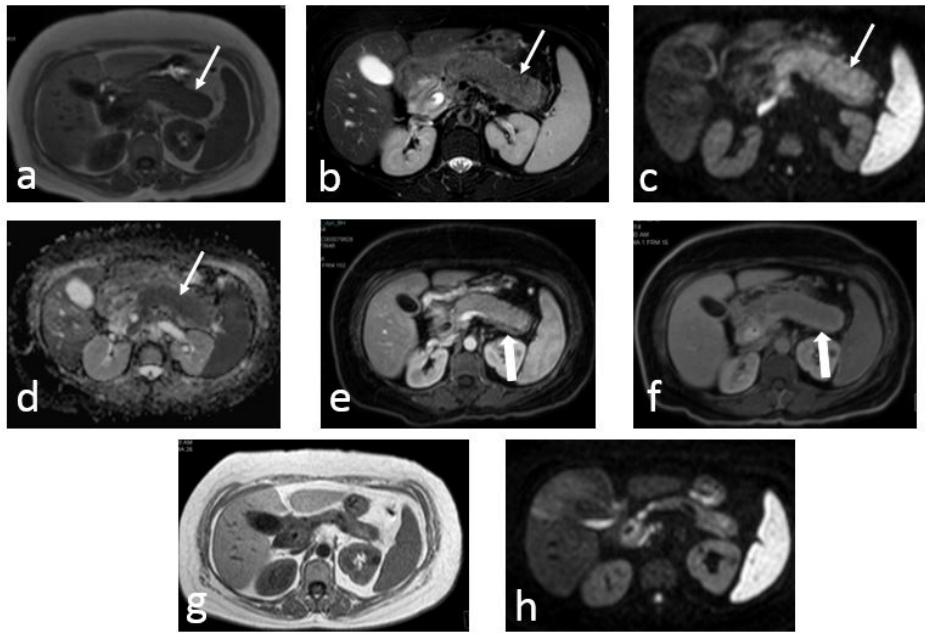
T1W axial MR image (a) shows hypointense and swollen pancreas with loss of normal peripheral lobulations (thin arrow). The tail of the pancreas shows a rounded contour. T2W image with fat suppression (b) shows a swollen pancreas with a hypointense peripheral rim. Intrapancreatic CBD is dilated with stent in situ. Diffusion weighted image with b value of 800 (c) shows diffuse hyperintensity of pancreas. ADC map (d) at the same level shows hypointensity suggestive of diffusion restriction. Post contrast image in pancreatic phase (e) shows diffusely hypoenhancing pancreas with a hypointense rim (thick arrow). In the delayed phase image (f) the peripheral rim is retaining contrast suggesting its fibrous nature. Based on these findings and elevated serum IgG4 levels diagnosis of autoimmune pancreatitis was made and the patient was treated with corticosteroids. The patient's symptoms resolved and follow-up images after three months (g and h) show significant reduction in the size of pancreas and normalization of diffusion.
